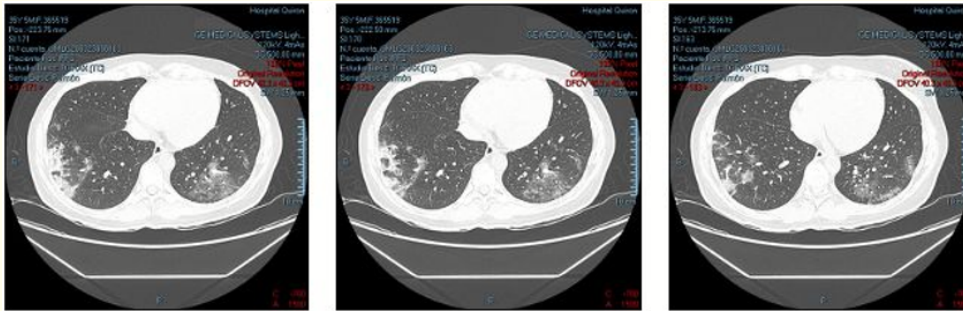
CT images demonstrating pneumonia consistent with COVID19 infection.
